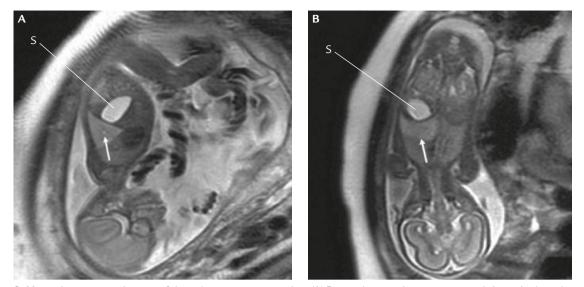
Magnetic resonance images of the pulmonary sequestration. (A) Prenatal magnetic resonance study in sagittal section of the pulmonary sequestration at 22^{+1} gestational weeks. (B) Coronal section of the pulmonary sequestration in the fetal lung. S = stomach.
